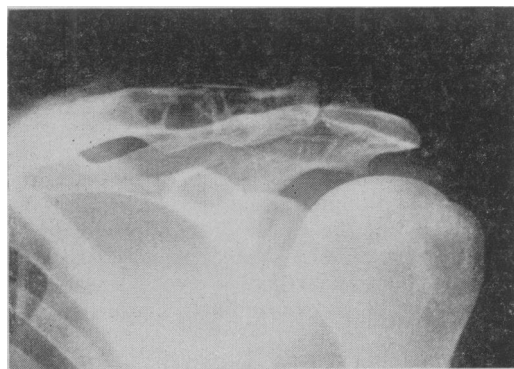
(Case V).—Radiograph showing cystic distension of the outer end of the clavicle.
